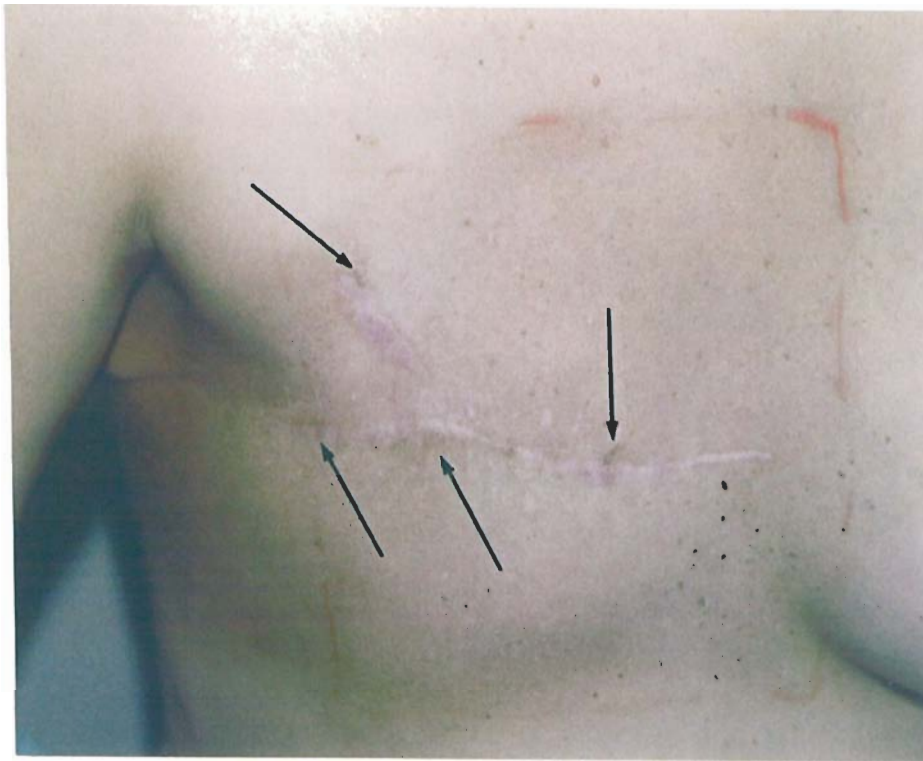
Multiple small early recurrences are present, chiefly around the stitch holes in the scar (arrowed). The treatment area is marked and the slight redness of the skin indicates the maximum skin reaction from combined microwaves and X-ray Therapy.
